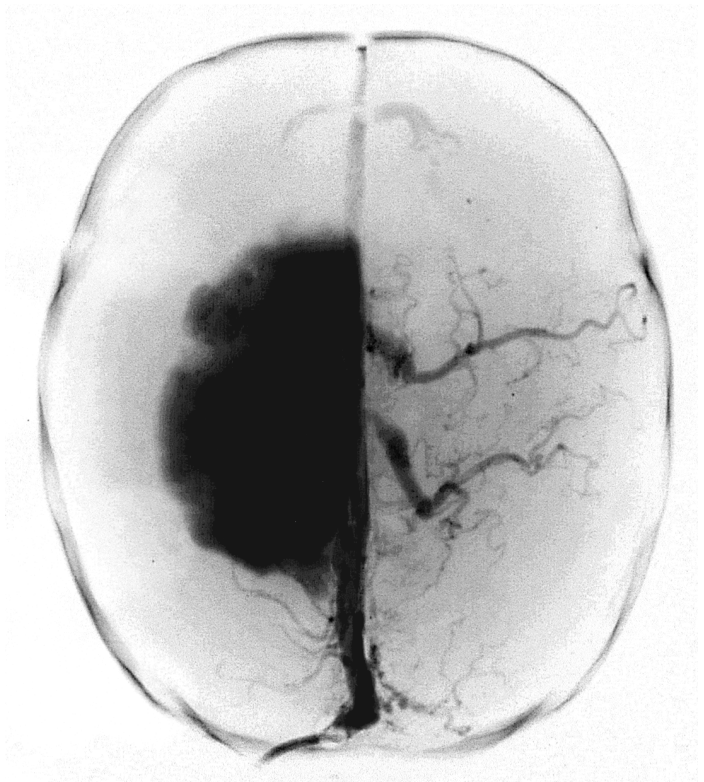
X-ray demonstration of a unilateral and well limited subdural extravasation of contrast material from parasagittal bridging vein ruptures. Case 2: probably shaken baby syndrome; survival time two weeks.
